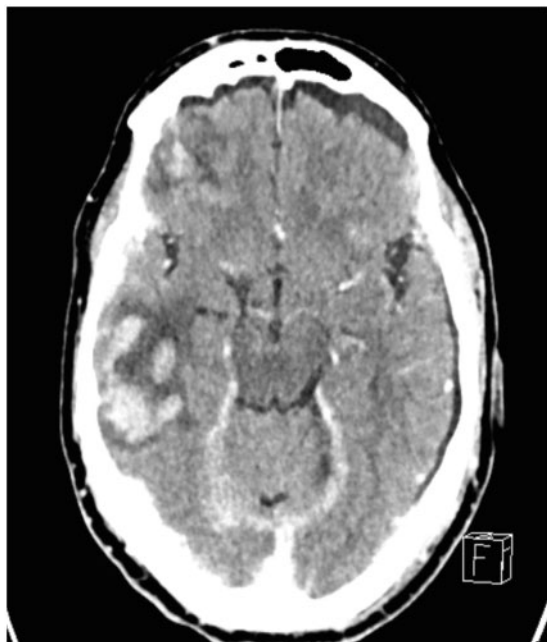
Emergent computed tomography scan showing bilateral post traumatic subdural and subarachnoid haematomas and right temporal intracerebral bleeding.
